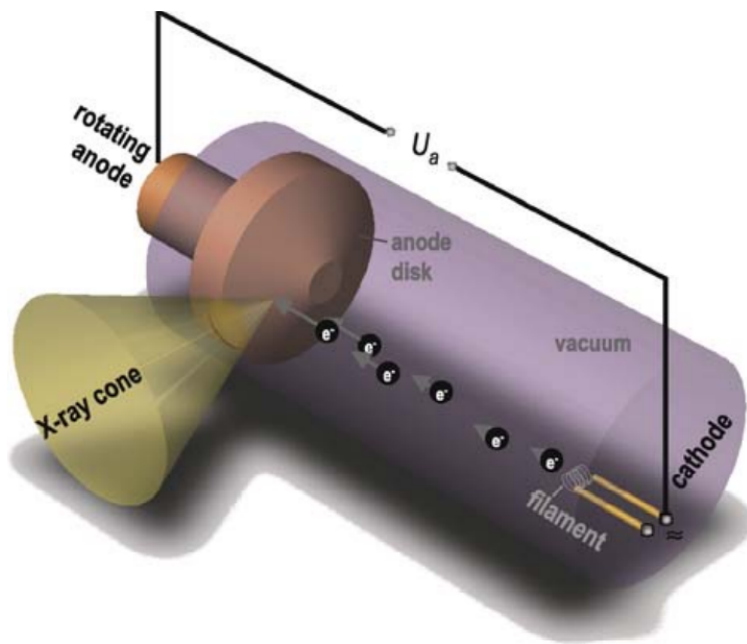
Sketch of an X-ray tube is shown. Thermal electrons are accelerated between cathode and anode. The deceleration due to their interaction with the anode results in X-ray emission. Figure adapted from [35].
